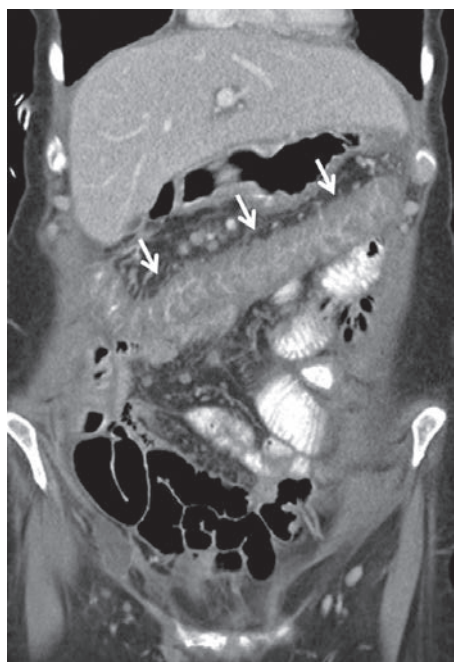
A 67-year-old woman with *Clostridium difficile* colitis. The patient had a history of recurrent ovarian cancer with associated sigmoid colon obstruction. She underwent sigmoid resection and diverting colostomy and a long course of antibiotics and developed abdominal pain, fever and diarrhea. Coronal CT performed with enteric and IV contrast demonstrates mural thickening of the colon with mucosal hyperenhancement, compatible with colitis. *C. difficile* titers were positive.
